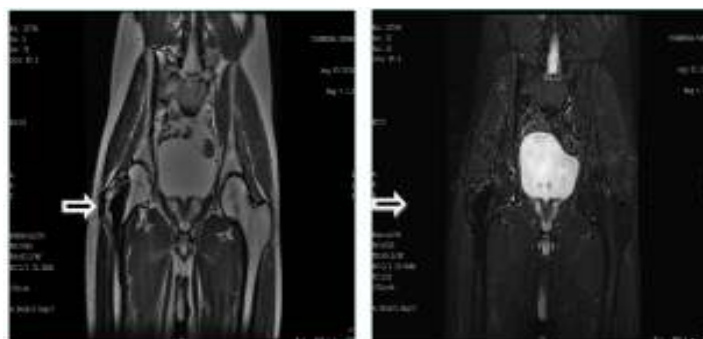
MRI of pelvis and both hip joints (t2w and stir coronal images) shows well defined geographical areas of hypointensities on t2w and stir seen in neck, greater and lesser trochanter as well as proximal part of shaft of right femur. normal signal intensity is seen on left side hip joint.
